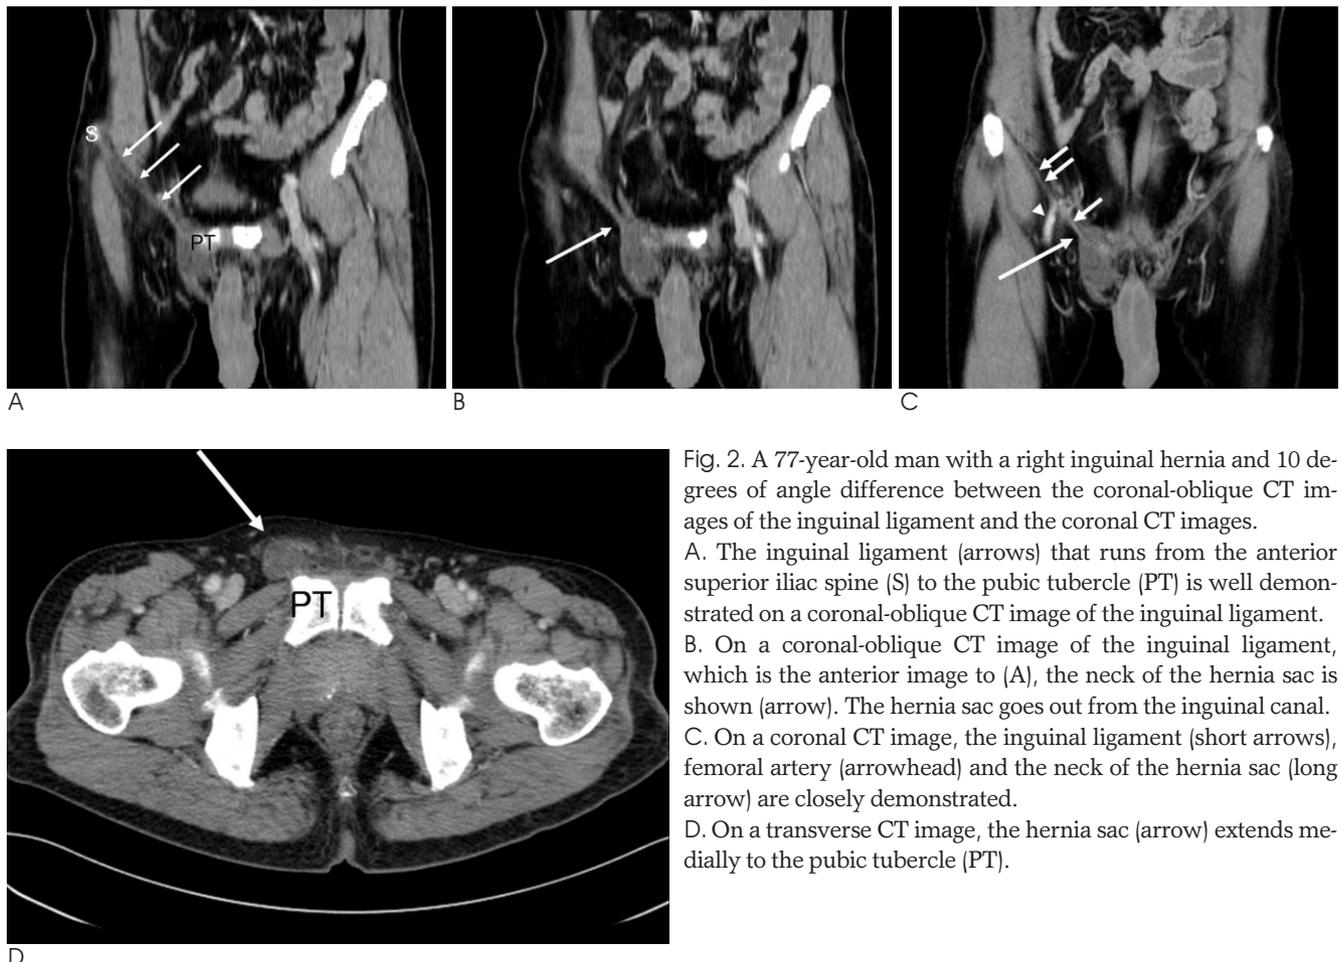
A 77-year-old man with a right inguinal hernia and 10 degrees of angle difference between the coronal-oblique CT images of the inguinal ligament and the coronal CT images.
